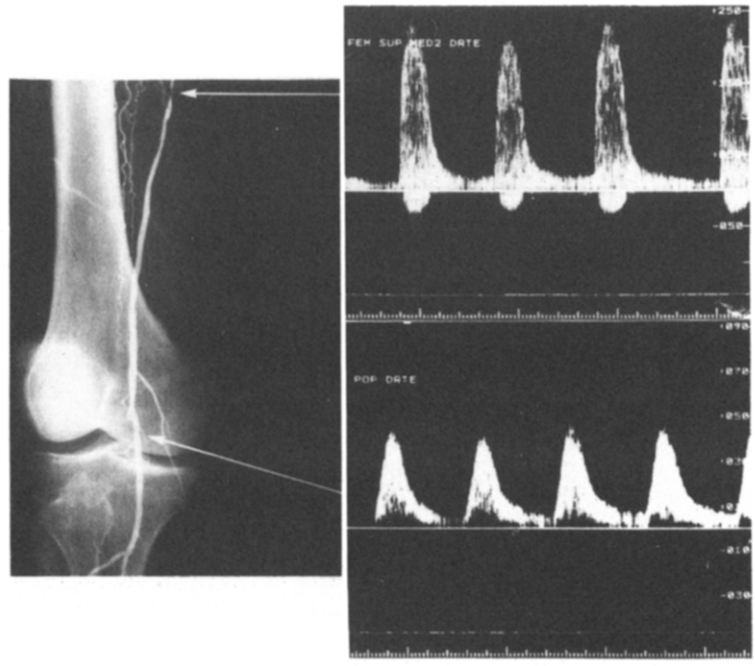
Angiography and Doppler scanning waveforms recorded from patient with 50% to 99% popliteal artery lesion that was misclassified (as normal) by duplex examination because of presence of severe superficial femoral artery lesion.
